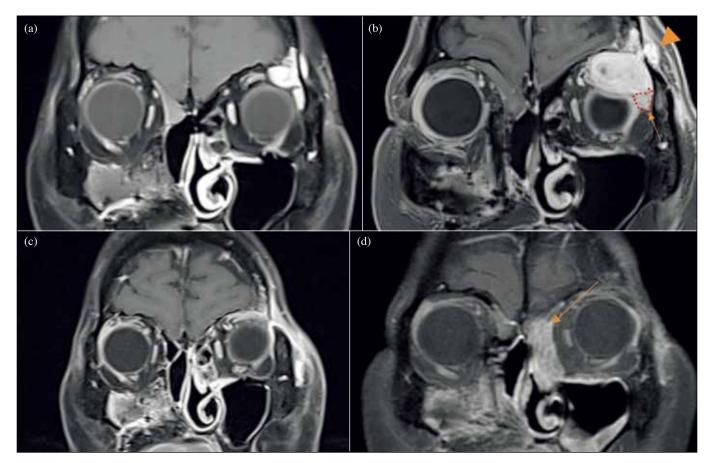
Post-contrast T1-weighted fat-suppressed coronal magnetic resonance imaging (MRI) of the orbit: (a) In December 2019, 1.5T MRI showing a homogenously contrast-enhancing lesion suspicious of lacrimal fossa tumor over the left lacrimal gland fossa with frontal bone involvement. (b) In March 2020, 3T MRI showing the enlarging lesion and ultra-fine anatomical details, including its subperiosteal location, a small cystic (necrotic) component, normal-looking lacrimal gland displaced inferiorly (arrow), and bony invasion at the frontozygomatic suture extending into the temporalis fossa (arrowhead). (c) In July 2020, 1.5T MRI showing the reduced subperiosteal lesion at 3 months after surgical excision. (d) In December 2020, 1.5T MRI showing no recurrence over the lacrimal fossa at postoperative 7 months, but new enhancing soft tissue (arrow) over the left medial orbit suspicious of metastatic deposit.
